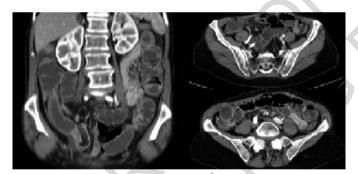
CT imagine of the last ileal loop intussusception.
